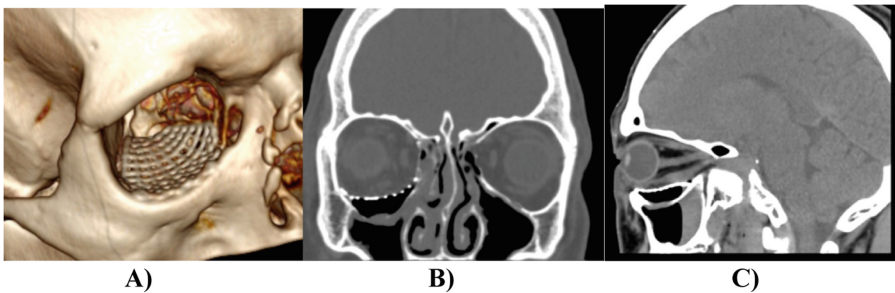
Postoperative CT examination: A) 3D reconstruction. B) Frontal sections. C) Sagittal section.
